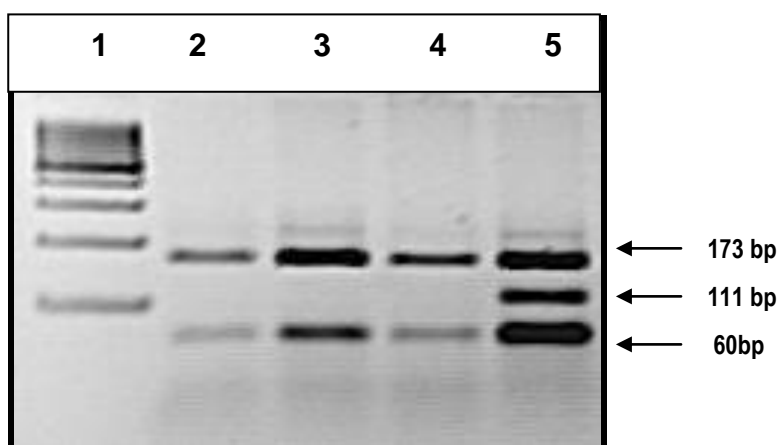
HphI* restriction enzyme analysis of c.975 C>T; p.Gly325Gly in the amplicon containing exon 13 resolved on a 3% (w/v) agarose gel. Lane 1 = 100 bp molecular weight marker (O'Generuler™, Fermentas); lanes 2, 3, 4 = CC, lane 5 = CT.
